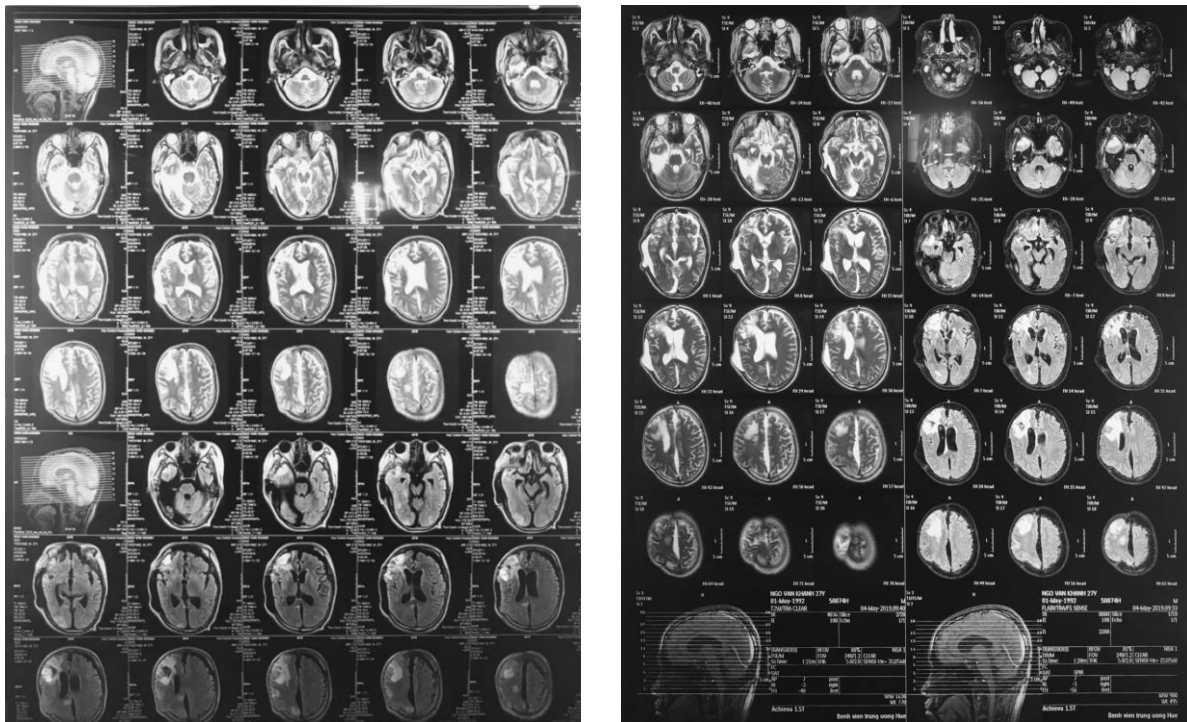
MRI results before and after treatment 6 months
